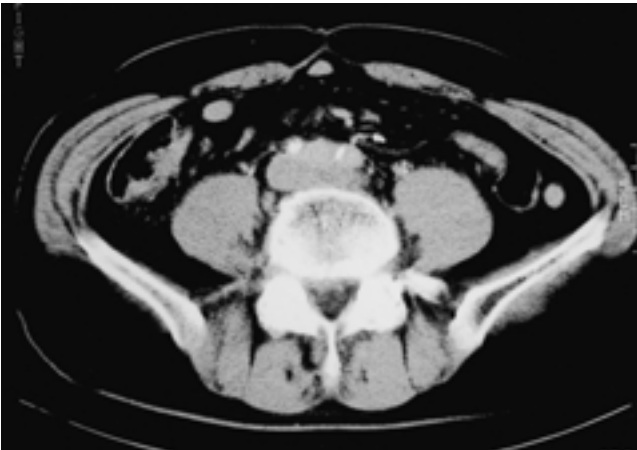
Abdominal CT scan shows metastatic aortocaval lymphadenopathy obstructing the IVC and both iliac veins.
